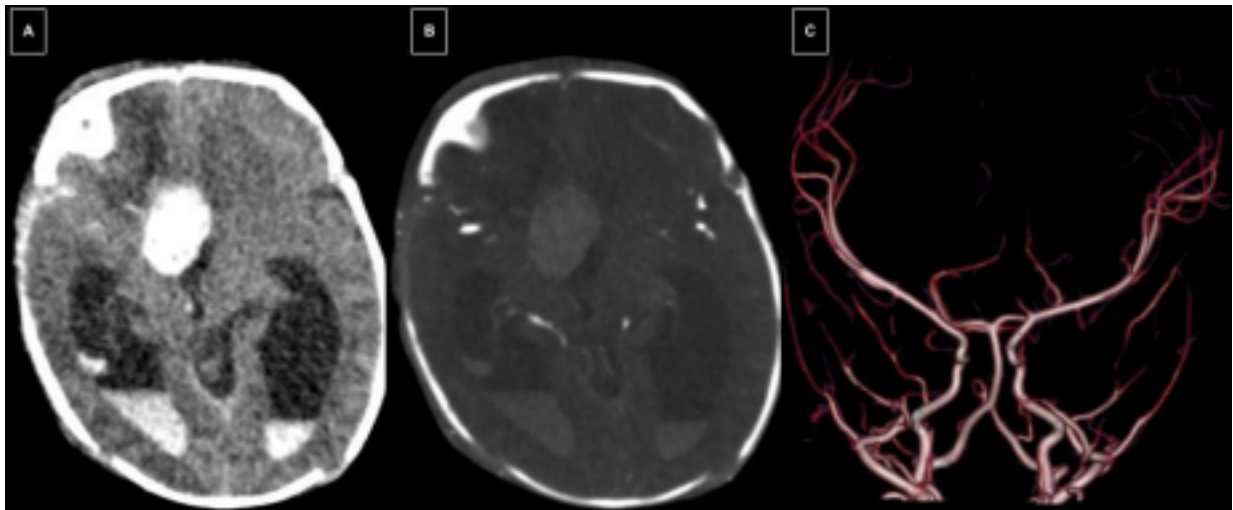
CTA. A) Noncontrast axial image. Enlarged hyperattenuating interhemispheric structure associated with similar findings in both ventricles, which was interpreted as remaining blood products. B) Axial image with contrast. Lack of enhancement of the aneurysm after the administration of intravenous iodinated contrast, finding that means it is thrombosed. C) 3D reconstruction CT. There are no signs of the aneurysm seen in the prior CT (Fig 3)
